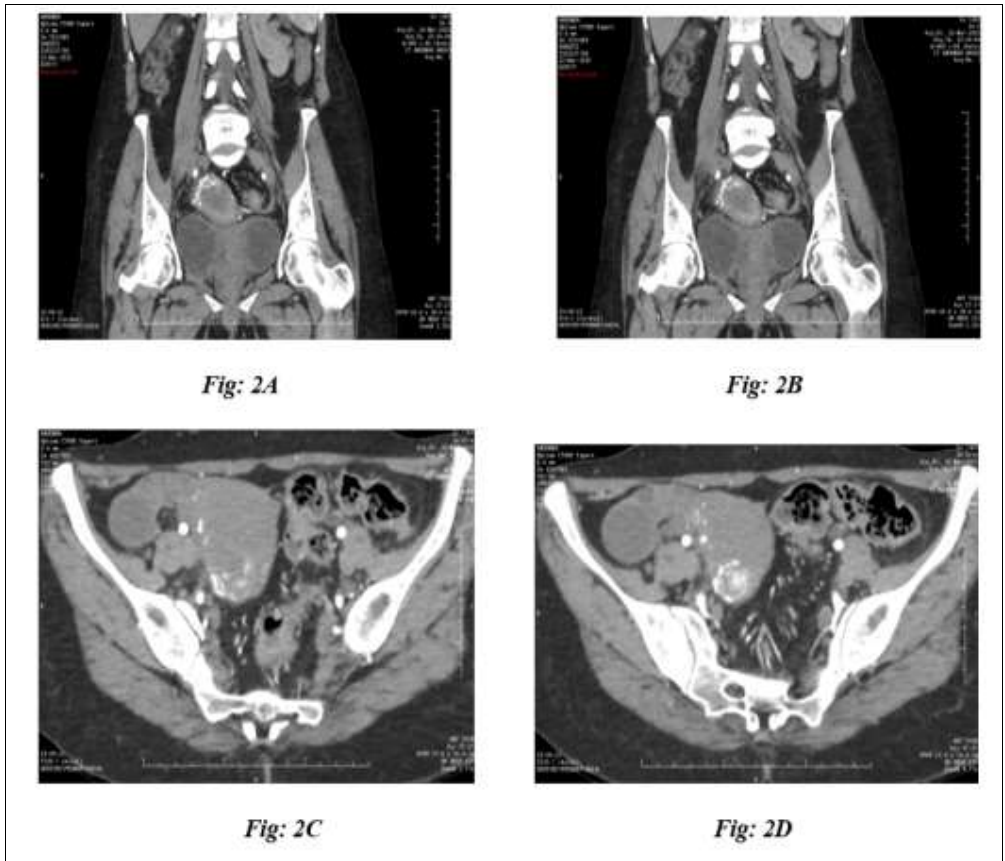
CT angiographic evaluation (coronal and axial images) demonstrating uterine AVM
